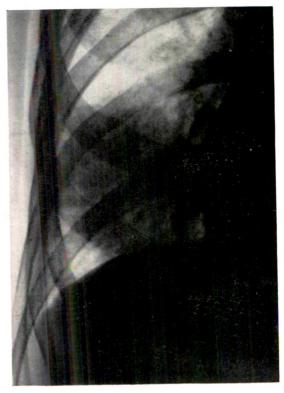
Postmortem roentgenogram showing two infarcts measuring 5 by 5 by 4 cm. and 3 by 3 by 2 cm., producing, when superimposed in the posteroanteric view, a rounded shadow.
